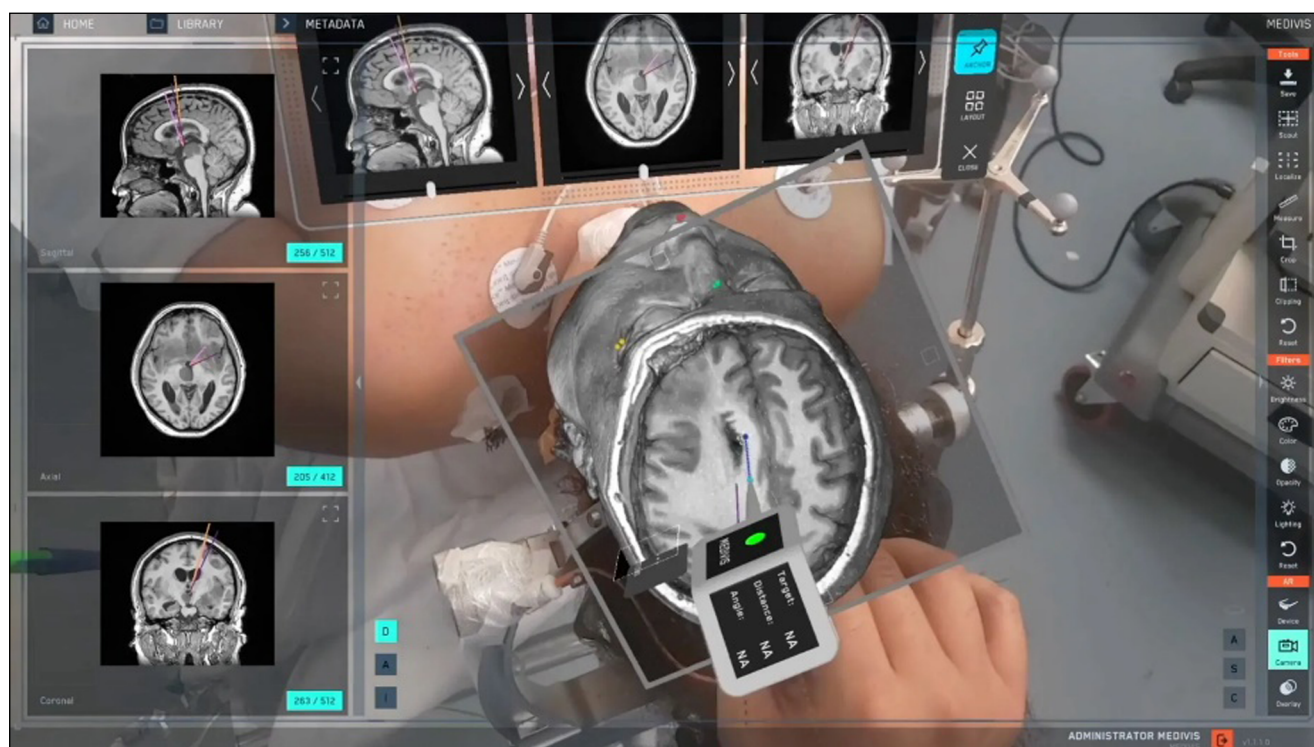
This figure demonstrates the use of an augmented reality surgical navigation platform (Medivis Spine Navigation Platform) that overlays segmented 3-dimensional anatomical structures onto the patient in real time. The system shown utilizes a preoperative computed tomography scan to create a volumetric model of the brain, which is then fused with the patient's physical anatomy using augmented reality. Multiple orthogonal imaging planes (sagittal, axial, and coronal) are displayed in parallel to guide precise targeting. The holographic overlay allows the surgeon to visualize deep structures without additional incisions or continuous fluoroscopy, enhancing spatial awareness and procedural accuracy. This fusion-based approach is particularly valuable in neurosurgery and other precision-demanding fields, where millimetric accuracy is essential. Reprinted with permission from Medivis SurgicalAR.
